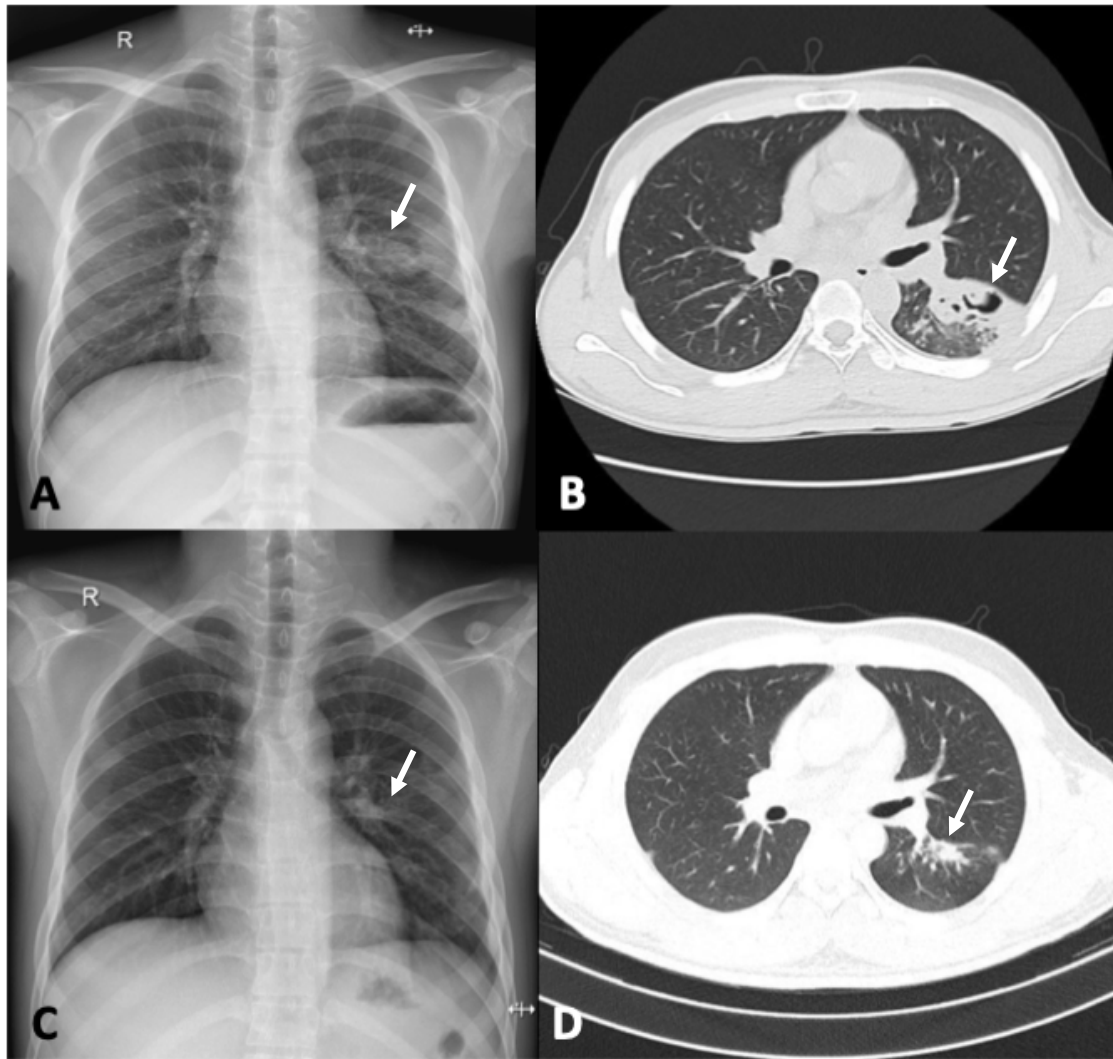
A. Chest X-ray on day of admission showed cavity with opaque lesion in the left perihilar lung (white arrow); B. HRCT on day 2 of admission showed multiple cavities with crescent sign, consolidation, and reticulonodular infiltrate on apicobasal left lung (white arrow); C. Chest X-ray two months after therapy showed improvement of consolidation (white arrow); D. HRCT five months after therapy showed resolution of crescent sign and stable condition of infiltrate on apicobasal left lung (white arrow).
